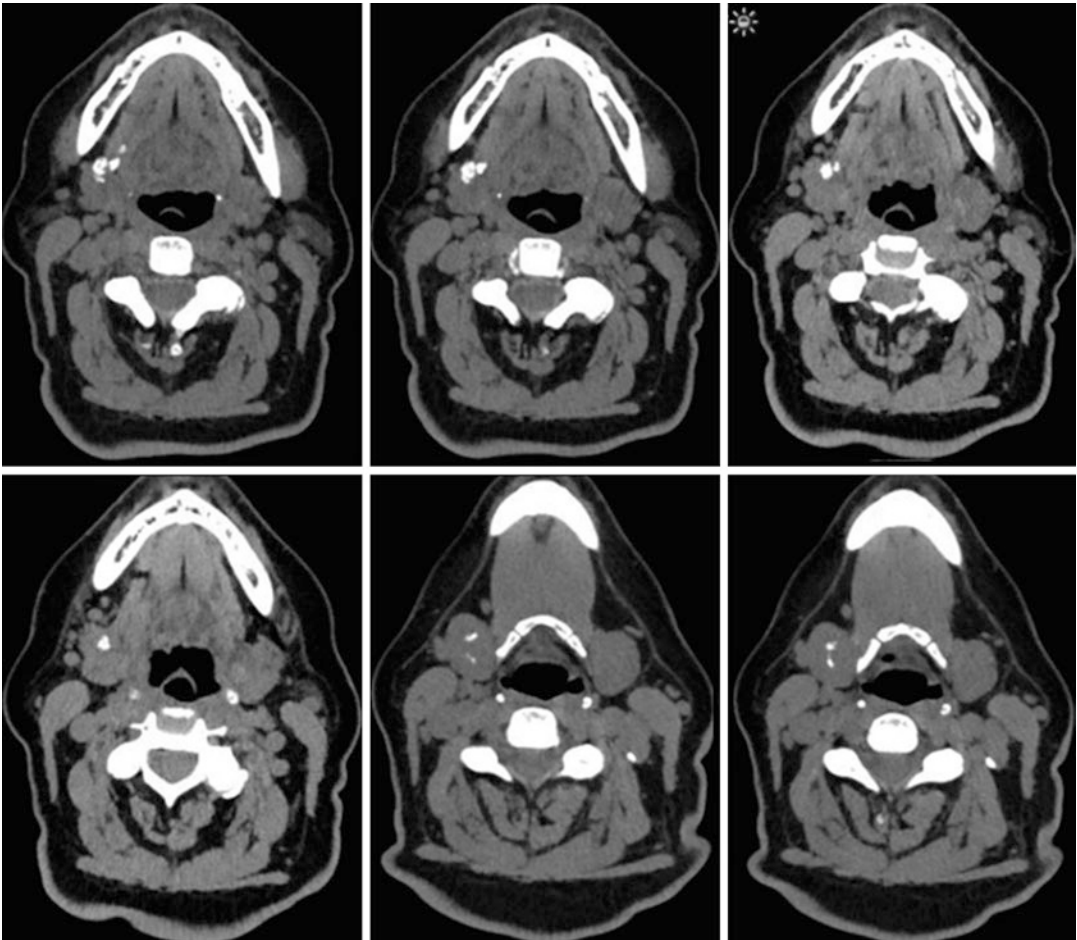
CT demonstrating the multifocal stones in the right submandibular gland
